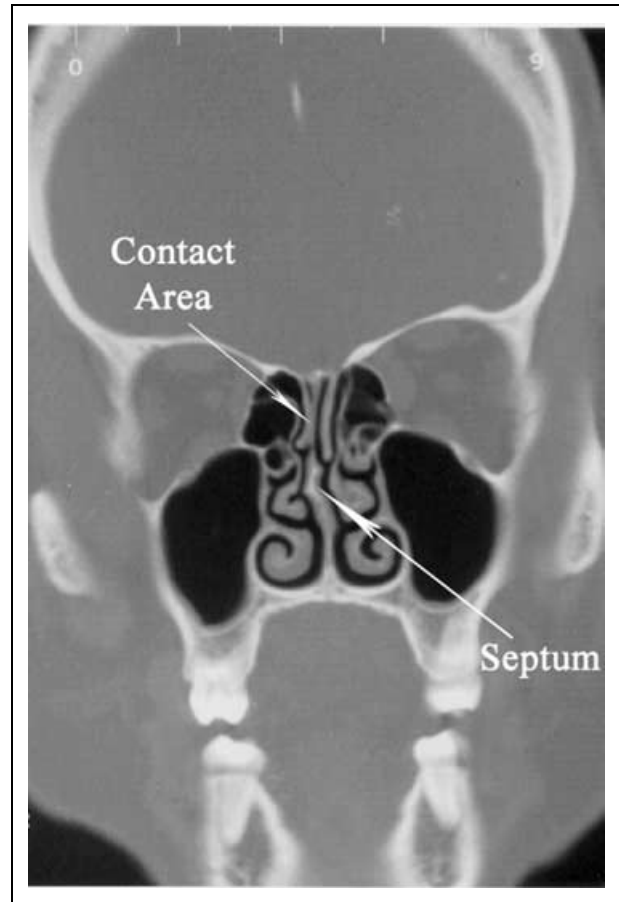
Shown above is a coronal CT of the sinuses. Note that this patient demonstrates contact between the superior turbinate and the septum on the right as shown by the arrow. There is also no contact between the middle turbinate and the septum.
